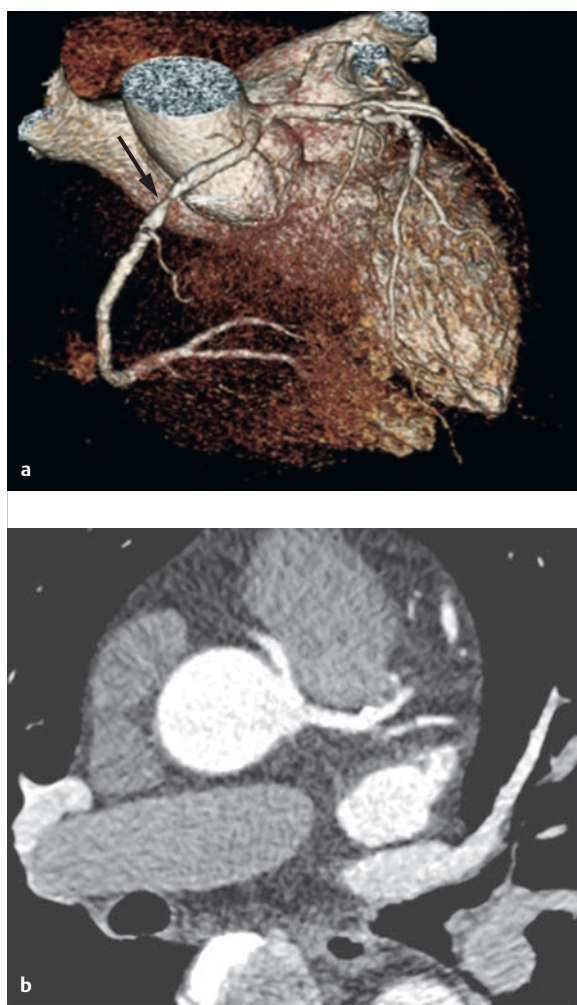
Common origin of the right coronary artery and left main branch from the left coronary sinus, with relevant coronary stenosis in the proximal right coronary artery. CT coronary angiogram.
